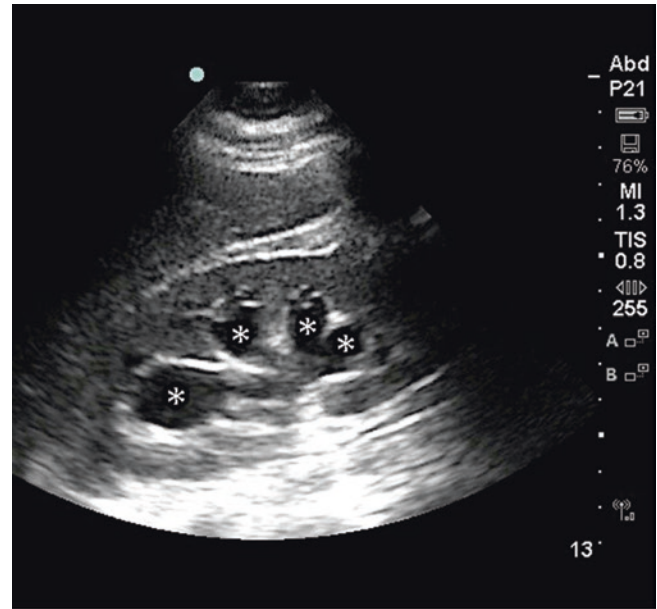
Ultrasound image of right-sided hydronephrosis in the longitudinal plane. Multiple anechoic (black) structures represent the renal calyceal system (*asterisks*), which is dilated due to renal stone obstruction at the ureteropelvic junction. Hydronephrosis can be categorized as mild (calyceal enlargement with preservation of renal papillae), moderate (calyceal rounding with obliteration of papillae, as in this image), or severe (calyceal ballooning with cortical thinning). See Video 28.5. (Image courtesy of Bret Nelson.)
